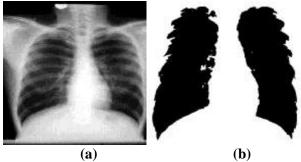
X-Ray Lung Image: (a) Applying gray-scaled. (b) Converting to binary image with applying Area opening filter.
